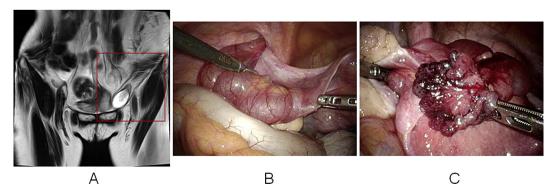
Preoperative imaging examinations and operative findings. (A) Magnetic resonance imaging showing a soft shadow in the left inguinal canal. The fallopian tube appears to be contained within the hernia sac; (B) left fallopian tube entering the inguinal canal along with the round ligament; and (C) the fallopian tube is dark red in color, suspicious for ischemia.
